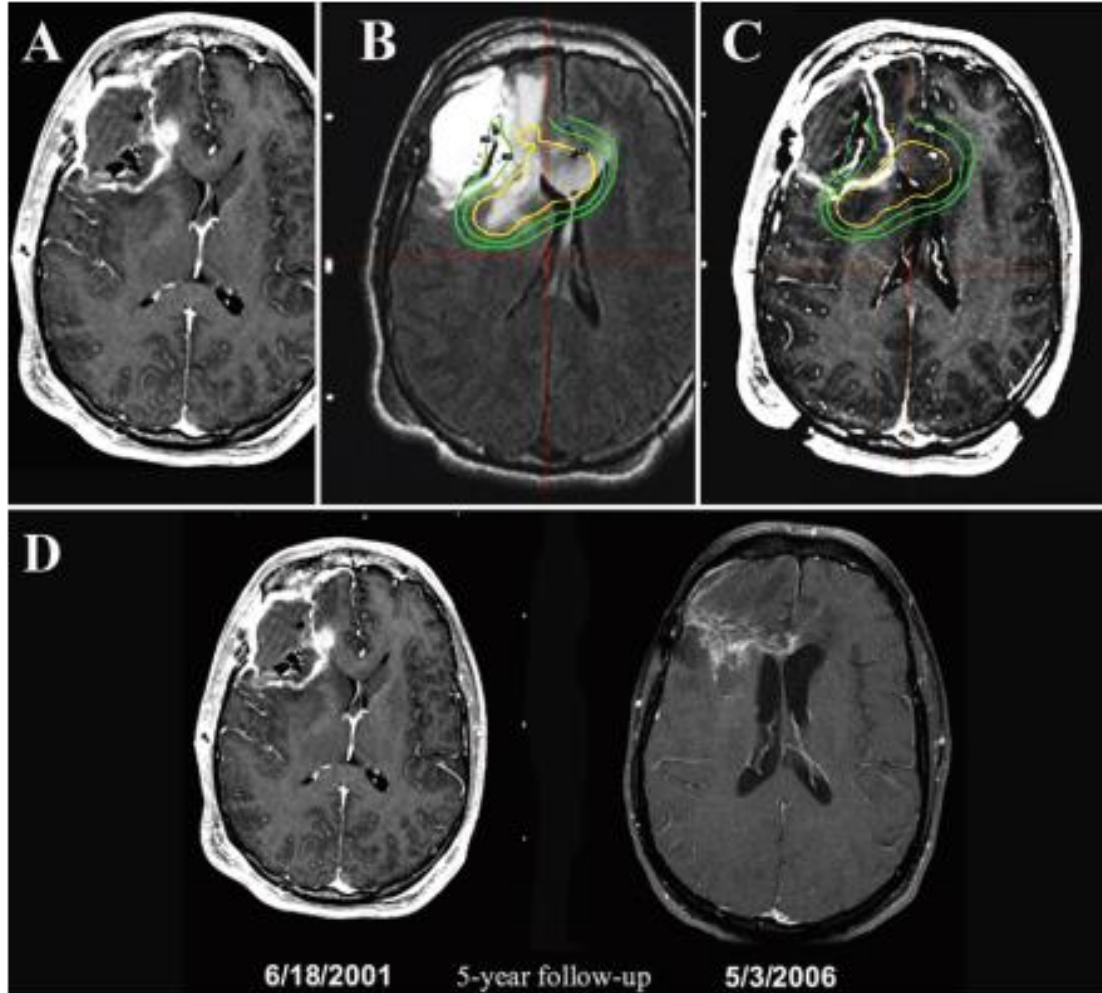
A: T1-weighted Gd-enhanced MR image obtained the day of Gamma Knife LERS showing postoperative 95% resection of the tumor bed. B: An LERS FLAIR sequence from the same day, showing “invisible” dramatic migration of tumor across midline and posteriorly down the corona radiata. The LERS plan is overlaid. The patient received 12 Gy at the 50% isodose line (yellow). C: The same LERS plan is overlaid on the T1-weighted post-Gd MR image, showing “invisible” tumor spread apparently treating normal brain. D: T1-weighted contrast-enhanced MR images, from the day of LERS and at 5 years later, respectively, showing residual scar tissue. This patient lived 8 years after treatment and ultimately died as a result of GBM progression.
